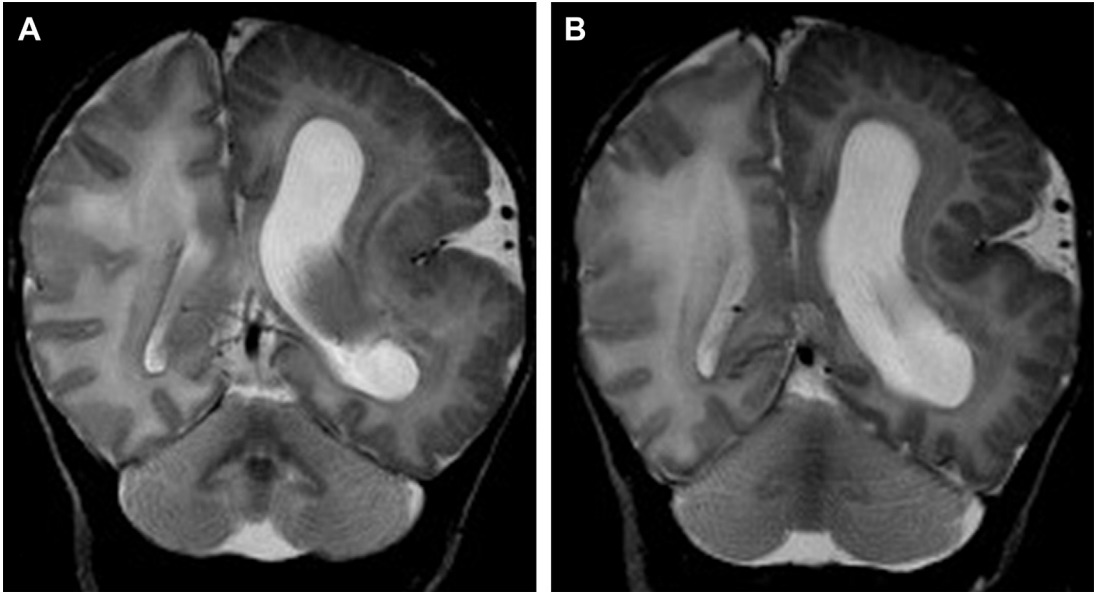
ENS. (A, B) Coronal T2-weighted images demonstrate total HME with enlargement of the cerebral hemisphere and ipsilateral cerebellar hemisphere. The enlarged cerebral hemisphere shows a thickened cortex with broad gyri, shallow sulci with blurring of the cortical-white matter junction, and T2-hyperintense signal of the white matter.
